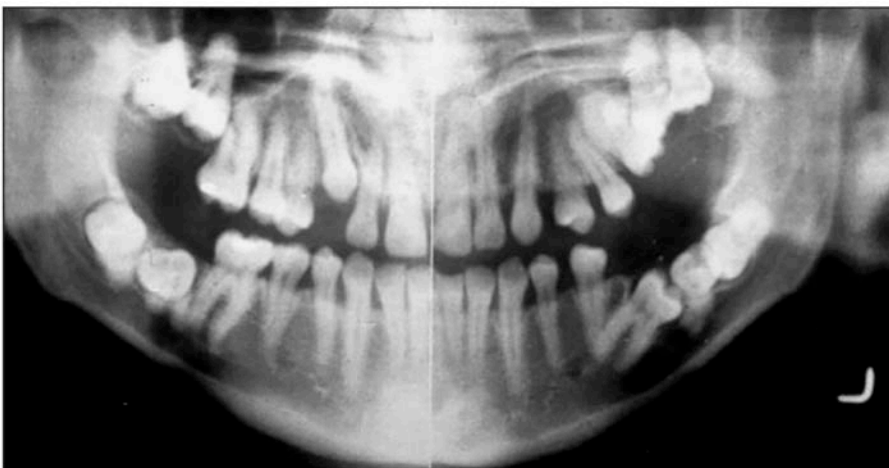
Panoramic radiographic image of multiple impacted molar teeth in various positions.
